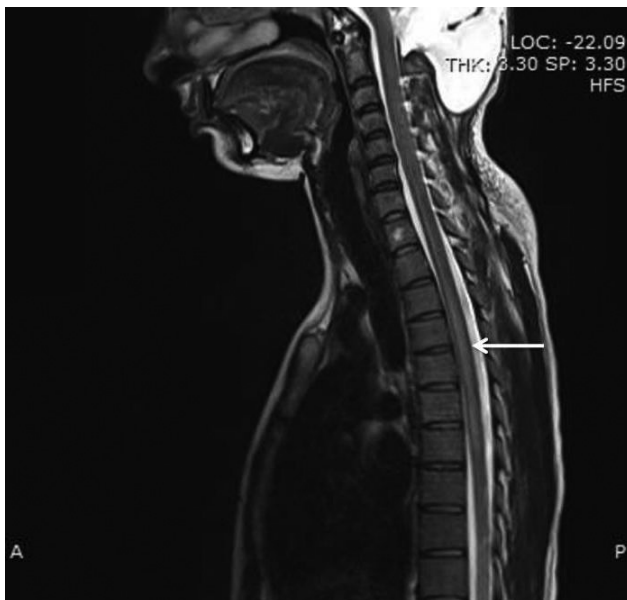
MRI spine showing edema in dorsal (D₃₋₈) cord. MRI, magnetic resonance imaging.
